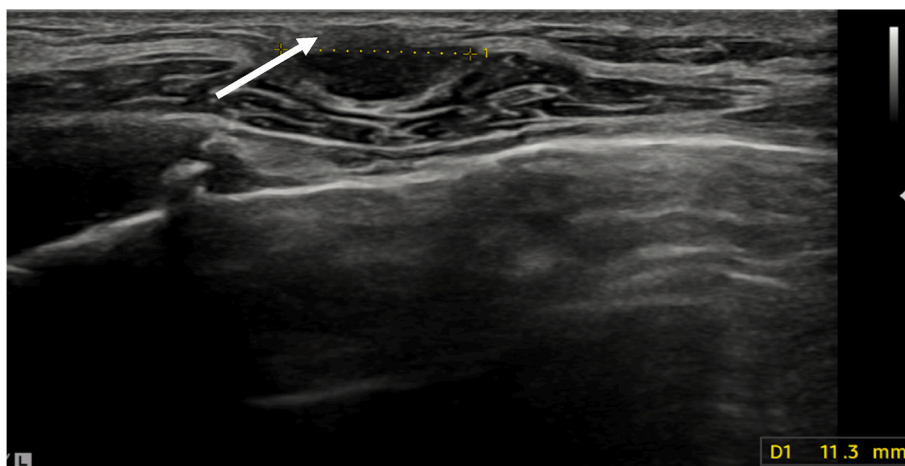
Ultrasound of left breast. 11 mm hypoechoic mass (marked with arrow). Reported as classification U3/4.
